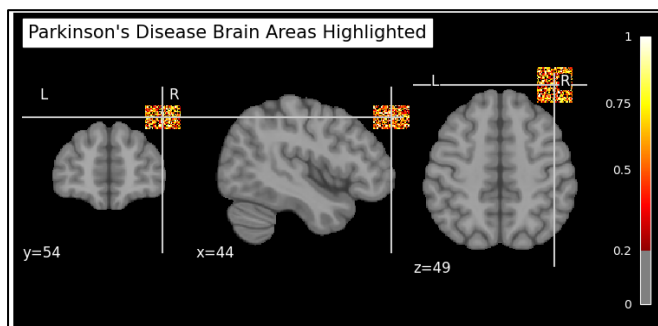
(a). Brain imaging slices for Parkinson's Disease diagnosis and analysis, highlighting key regions with structural MRI-based processing. Subfigures A, B, and C represent coronal, axial, and sagittal orientations, respectively.
